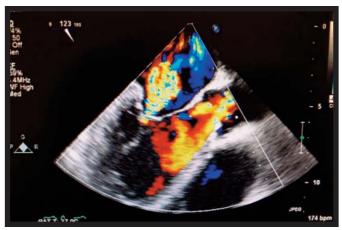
Preoperative echocardiographic view of the regurgitant aortic and mitral valves
